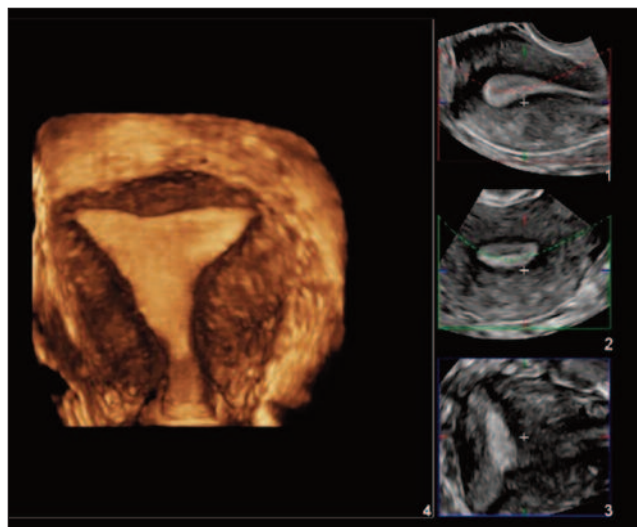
Transvaginal three-dimensional (3D) ultrasound showing a complete endometrial image.
